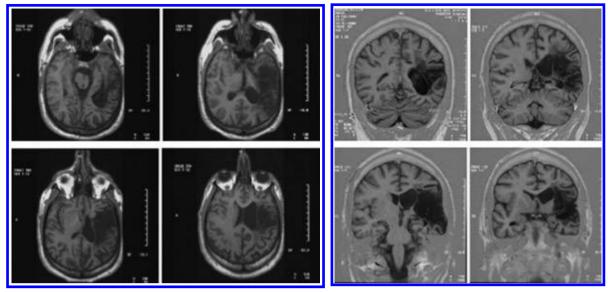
Axial and coronal magnetic resonance imaging (MRI) scans of KL's left frontoparietal lesion, taken 3 years post-stroke. The right hemisphere appears on the left-hand side of the scan.
